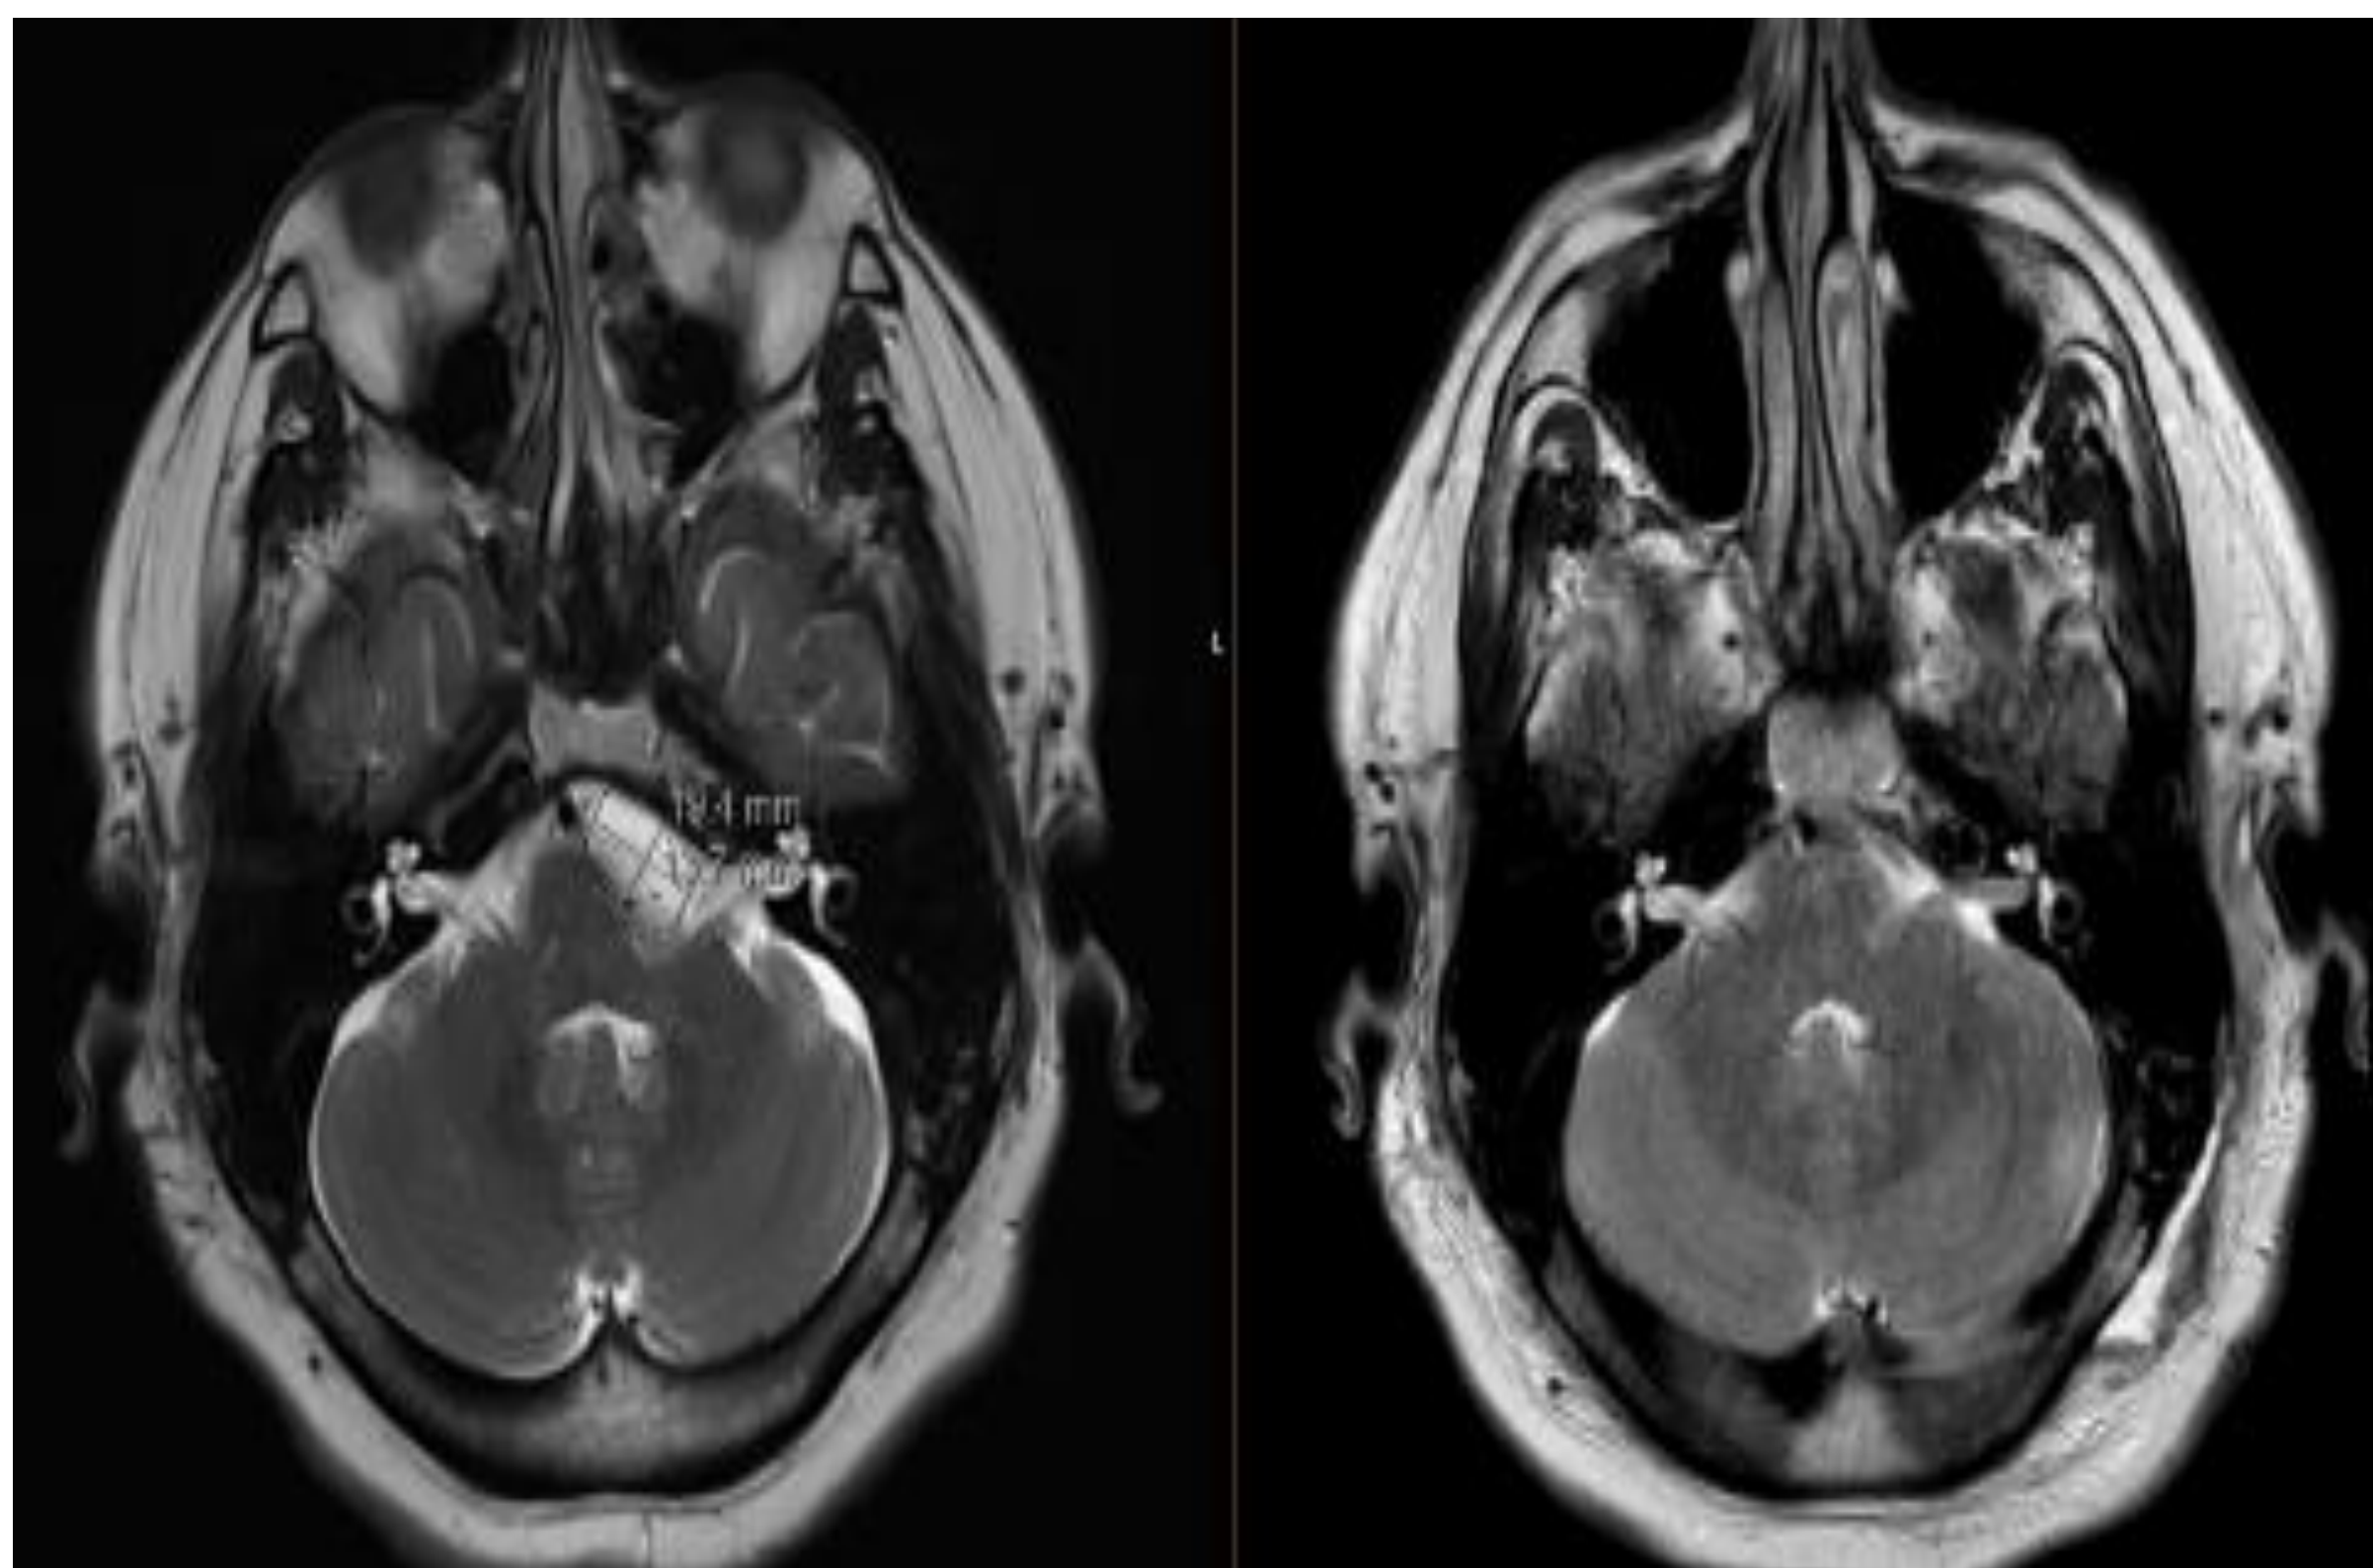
A. T2 axial MRI pre and post-left retrosigmoid craniotomy.
